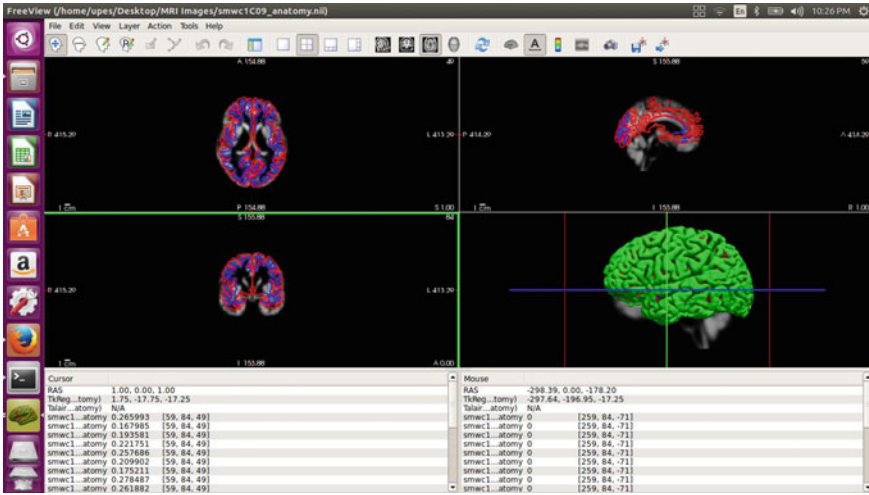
Grey matter in the functional MRI
